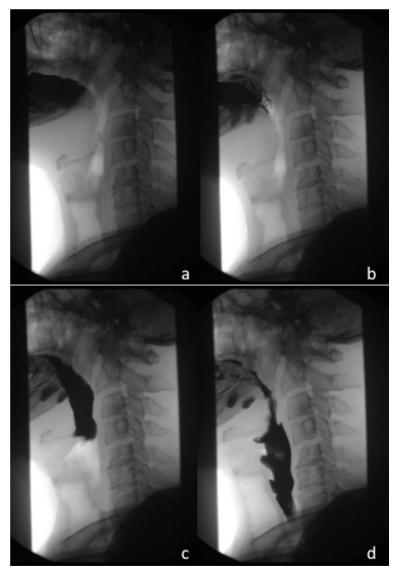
Lateral radiographic overview of a normal swallowing sequence of a healthy patient with 10mL of barium. (a) Barium bolus is positioned in the mouth and is sealed off from the throat by approximation of the tongue with the soft palate. (b) The soft palate opens, allowing barium into the oropharynx. (c) Pharyngeal phase of swallowing has commenced. The upper oesophageal sphincter is open allowing free passage of fluid. (d) Peristaltic activity in the cervical oesophagus propels bolus into stomach. Adapted from Hellerhoff¹
